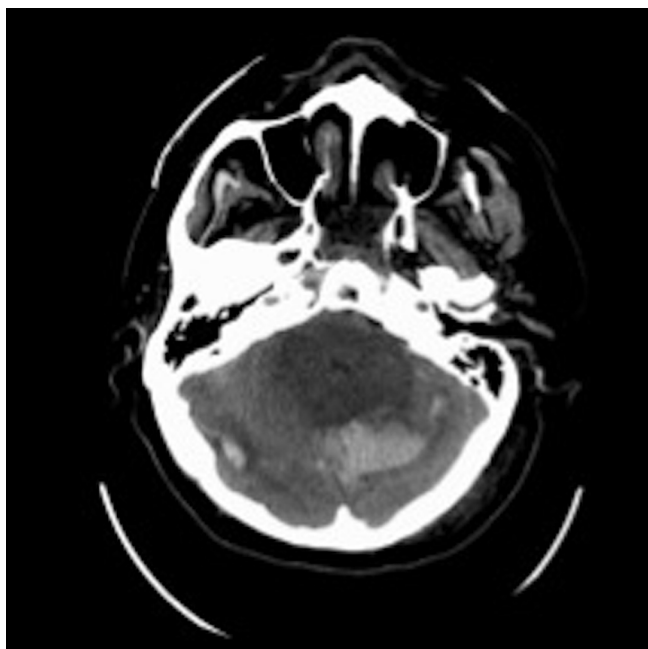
Patient 1. Axial head CT scan on the fourth postoperative day showing evolution of the remote cerebellar hemorrhage with effacement of the fourth ventricle and perimesencephalic cisterns.
